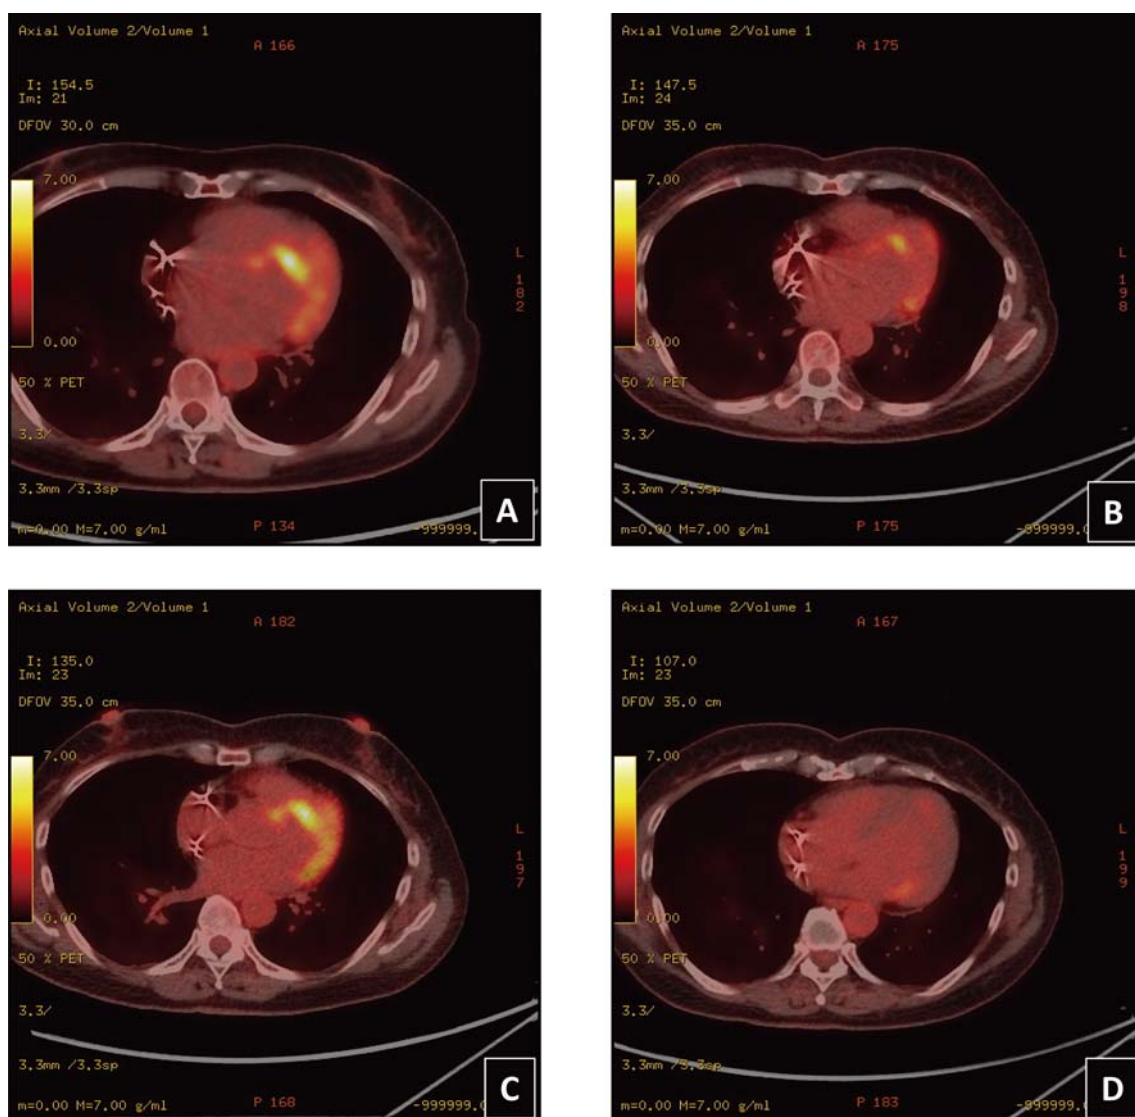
Serial ^{18}F -FDG PET/CT imaging of active cardiac sarcoidosis.
